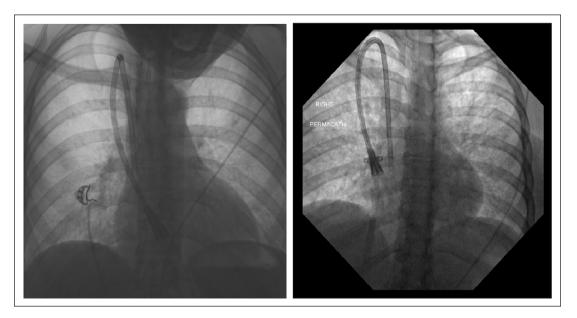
Chest X-rays of 'Patient 2' showing the haemodialysis catheter inserted with a paramedian tunnel, with frontal view (left) suggesting a catheter kink but lateral-oblique view (right) confirming a wider curve.
